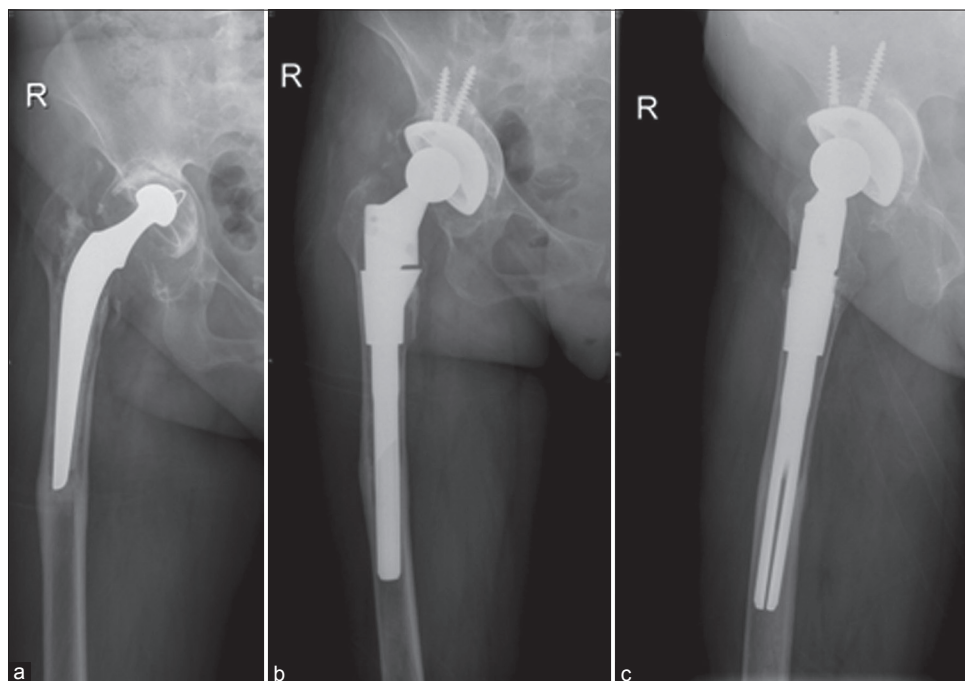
Preoperative radiograph (R) hip with thigh showing (a) loosening and Paprosky type 2c defect 17 years post total hip replacement in a 56-year-old lady (b) Followup at 1 year postoperative lateral (c) showing graft integration
